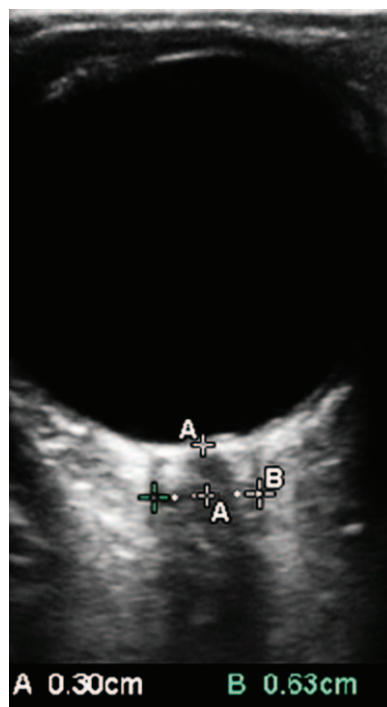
Ultrasonographic optic nerve sheath. The optic nerve sheath is observed as a vertical hypoechoic band. The optic nerve sheath diameter (B) is measured 3mm behind the optic disc (A).
